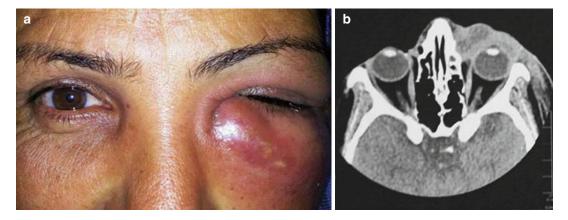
(a) Photograph of a 38-year-old woman with 1-week history of acute dacryocystitis shows left inferior eyelid edema and erythema. (b) Axial CT scan shows left
